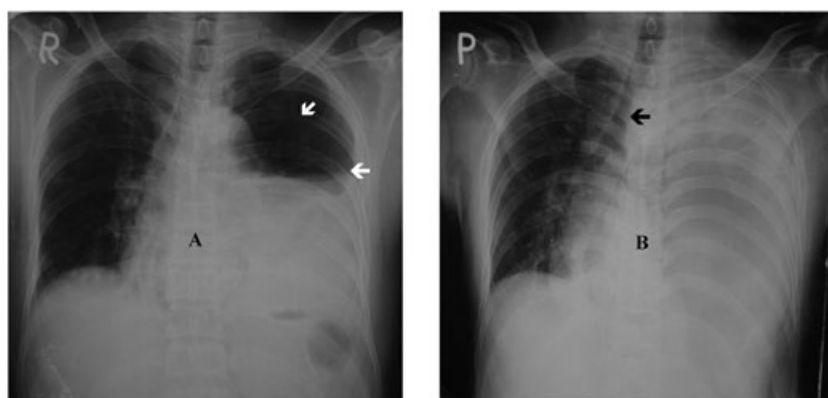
Two consecutive chest radiographs with tension hydropneumothorax. A) Chest radiograph on admission in the tertiary hospital with left hydropneumothorax, the visceral pleura edge is discernible (white arrows). B) A supine chest radiograph taken 22 h later shows left hemithorax white-out and increasing tracheal deviation to the right (black arrow).
